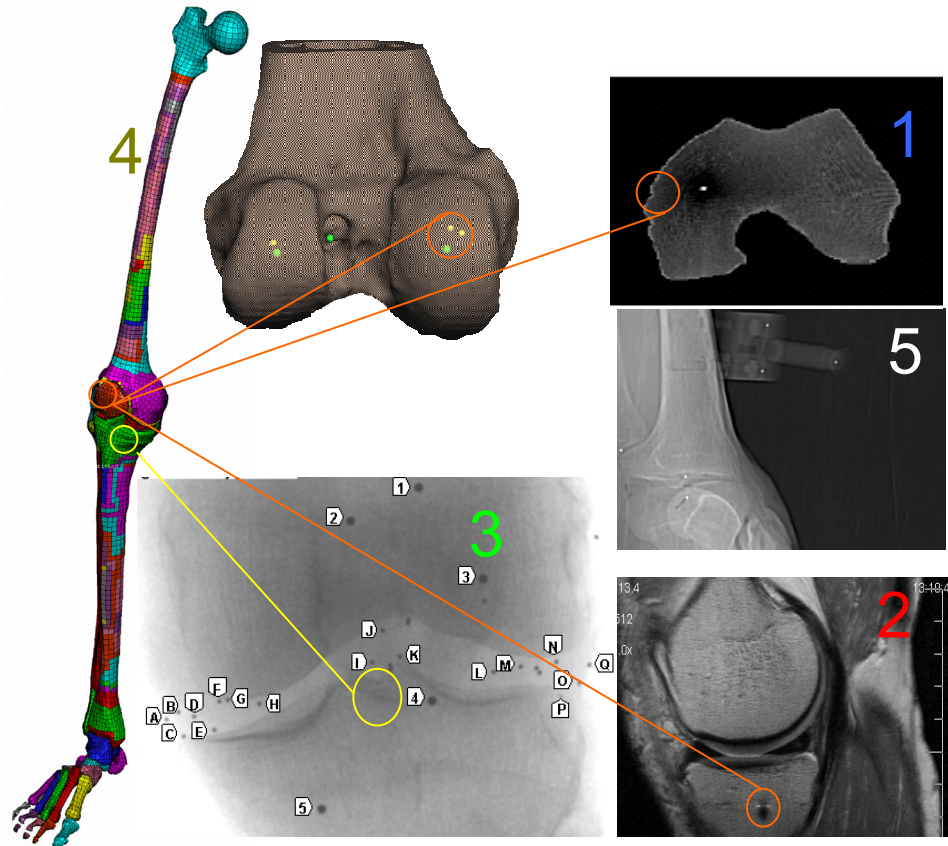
Image fusion process to deliver higher mesh density and patient specificity in the development of the solid model:1) Computed tomography data 2) MRI data 3) Image from menisci and Anterior cruciate ligament with tantalum beads from the DRSA system, 4) The Whole Lower limb FE model and the reconstructed femur bone surface data, 5) Note the presence of tantalum markers in all imaging modalities for co-registration (Cupric Sulfate tube).
